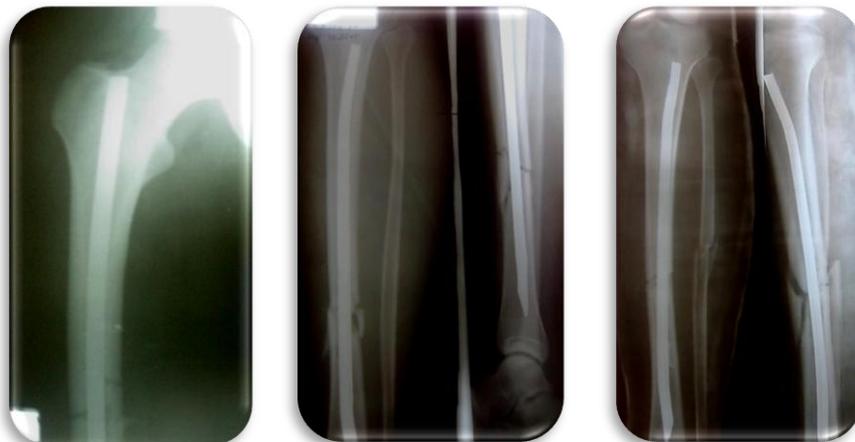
Immediate postoperative X-rays the right thigh and both tibia after intramedullary osteosynthesis (standing of bone fragments is satisfactory)
